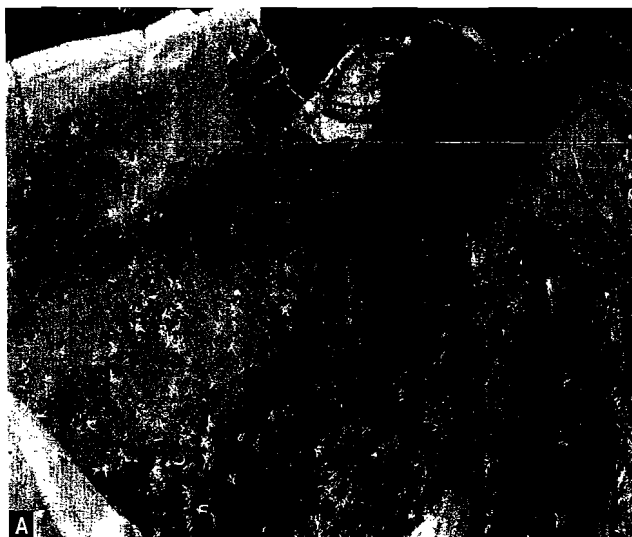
Ultrasound zones of thorax
